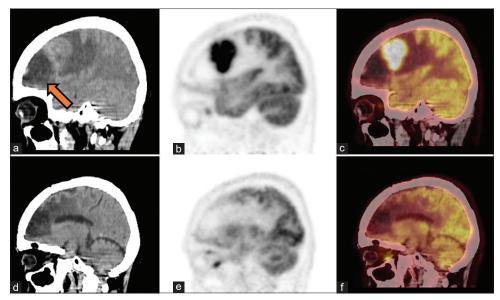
(a) Axial noncontrast computed tomography (CT). (b) F 18 fluorodeoxyglucose positron emission tomography (FDG PET) and (c) fused F 18 FDG PET CT showing intense FDG uptake in a hyperdense lesion in the left frontal region, associated with disproportionate perilesional edema. Note made of non FDG avid postoperative collection anterior to the lesion.(orange arrow). (d) Axial noncontrast CT. (e) F 18 FDG PET and (f) fused F 18 FDG PET CT showing complete resolution of lesion on follow up scan
